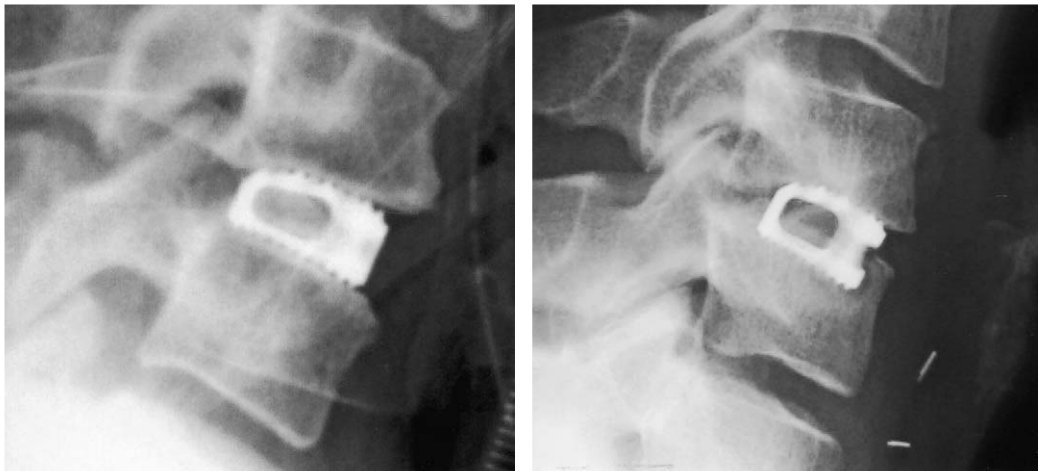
Radiograph of a SynCage C, a) directly postoperative and b) after 6 months follow-up showing subsidence into C7 (van Jonbergen *et al.*, 2005)
